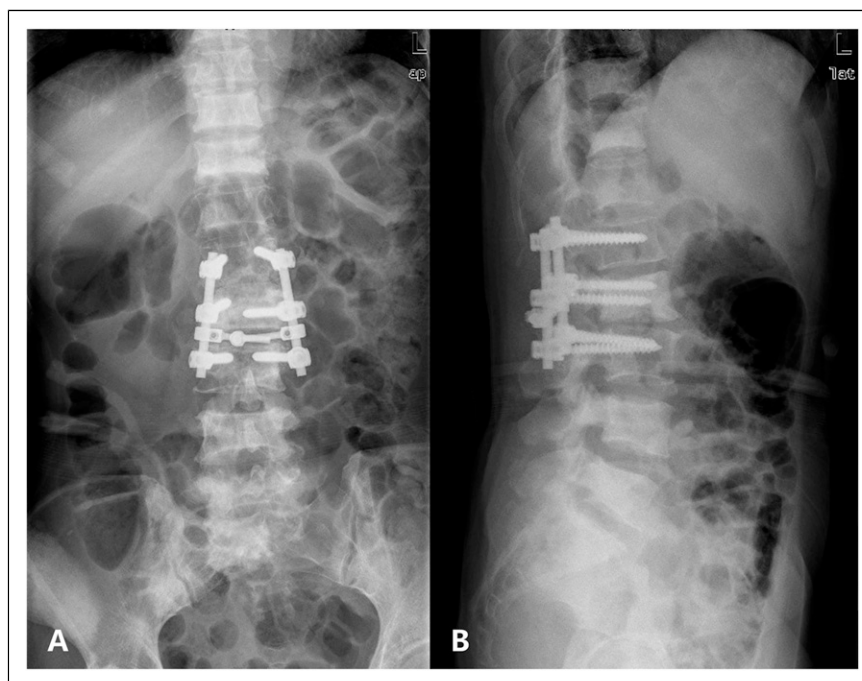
Postoperative anteroposterior radiograph following instrumented stabilization (A). Postoperative lateral radiograph following instrumented stabilization (B).
